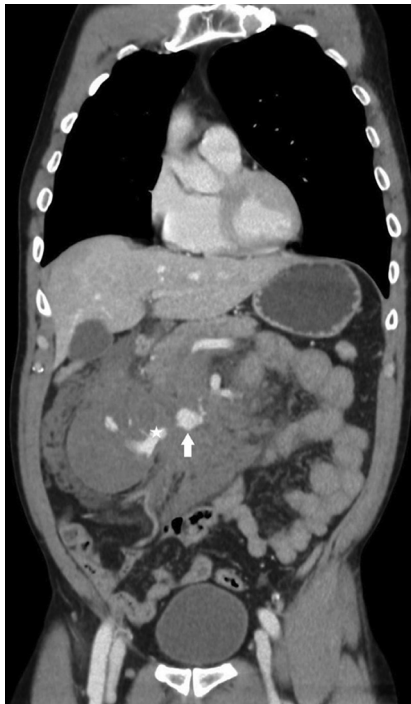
Contrast-enhanced abdominopelvic CT, axial image, arterial phase: Huge retroperitoneal and mesenteric hematoma located on the right side with a pseudoaneurysm of the pancreaticoduodenal arcade (arrow)
